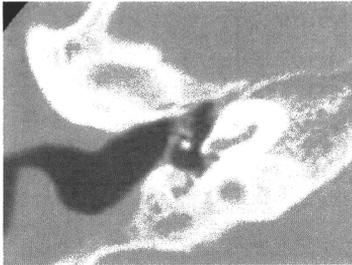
Computed tomography on August 29, 2008 demonstrated good aeration in the tympanic cavity.
